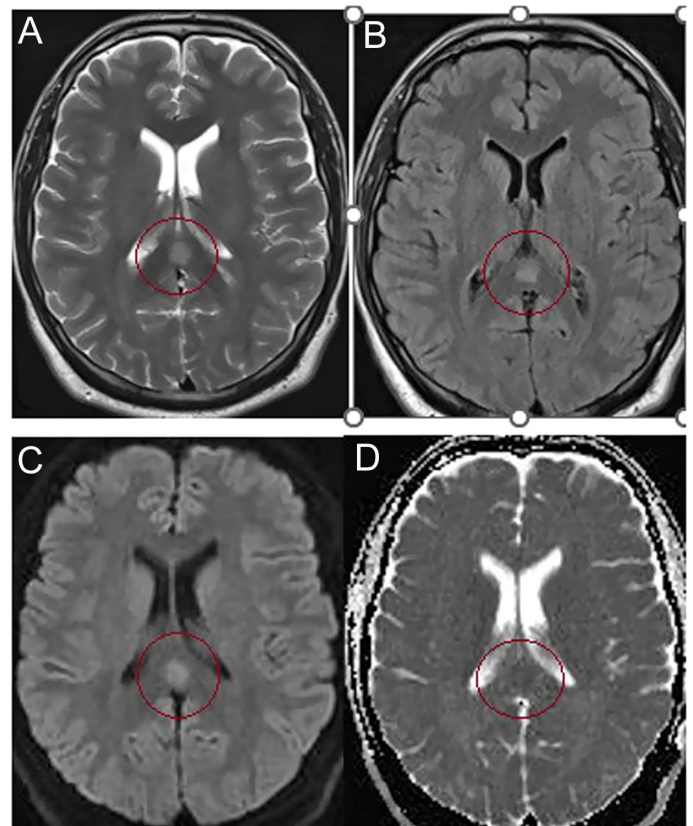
Magnetic resonance imaging shows a round lesion in the mid-splenium of the corpus callosum, which is hyperintense on T2-weighted (A, circle) and fluid-attenuated inversion recovery (B, circle) images. The lesion reveals restricted diffusion with a hyperintense signal on diffusion-weighted imaging (C, circle) and a hypointense signal on the apparent diffusion coefficient map (D, circle).
